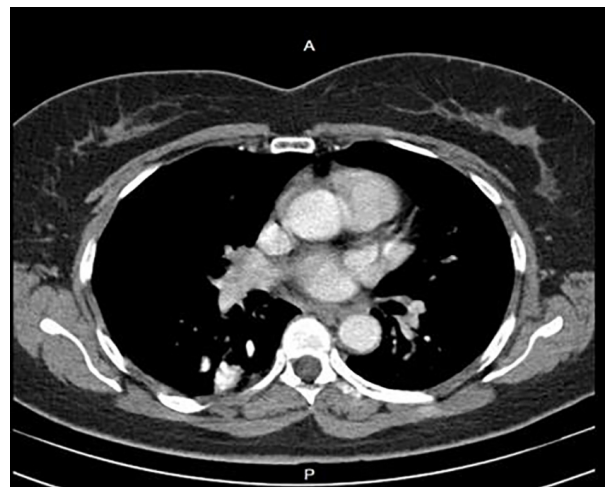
CT scan 3 years after completing treatment.
